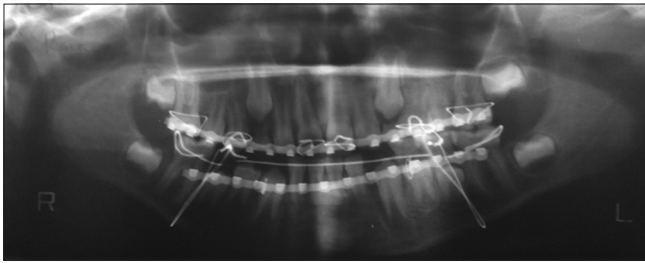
Panoramic X-ray show circummandibular wiring
